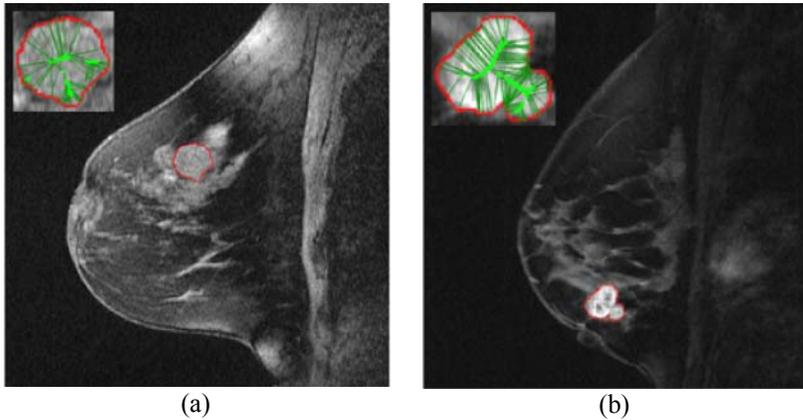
DCE-MRI postcontrast images with insets of lesions delineated (red) and medial axis (green) for (a) benign and (b) malignant lesions.
